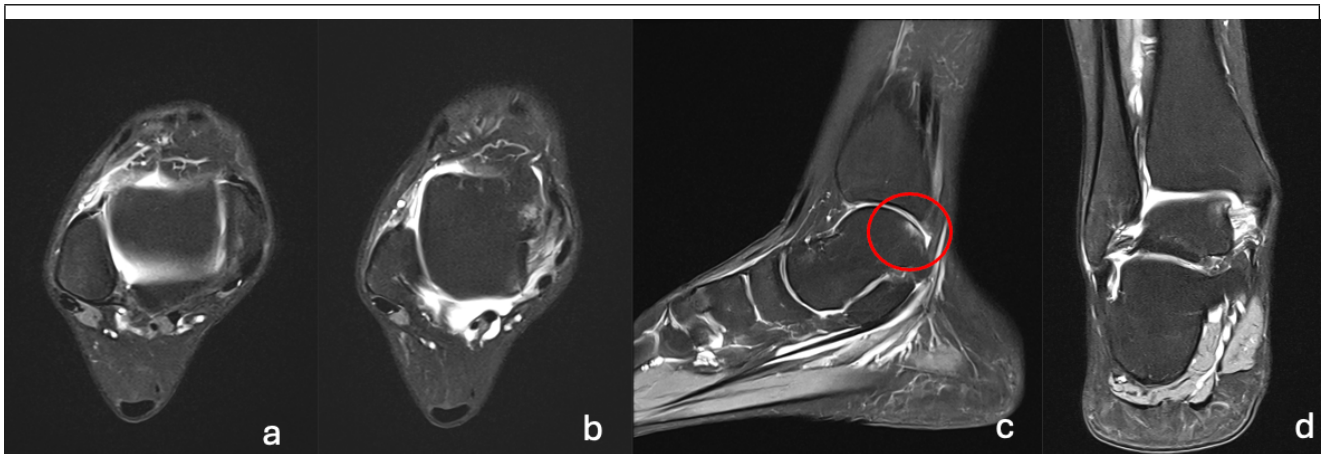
A 40-year-old female patient presented with an acute inversion-type ankle injury. Magnetic resonance imaging (MRI) was performed in the hyperacute period. Axial (a, b), sagittal (c), and coronal (d) sequences reveal a partial-to-complete disruption of the anterior talofibular ligament (ATFL). There is prominent subcutaneous and periarticular soft tissue edema, as well as marked tibiotalar joint effusion. Additionally, diffuse medullary trabecular edema (highlighted with a red circle) is observed within the talus, consistent with acute bone marrow edema.
